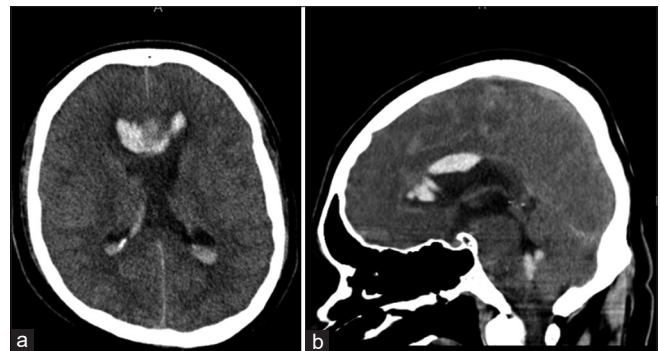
Head computed tomography without contrast showing redemonstrations of subarachnoid hemorrhage from the proximal largest aneurysm, effaced basal cisterns and an interval increase in both hydrocephalus and cerebral edema. (a) Axial view, (b) sagittal view.
